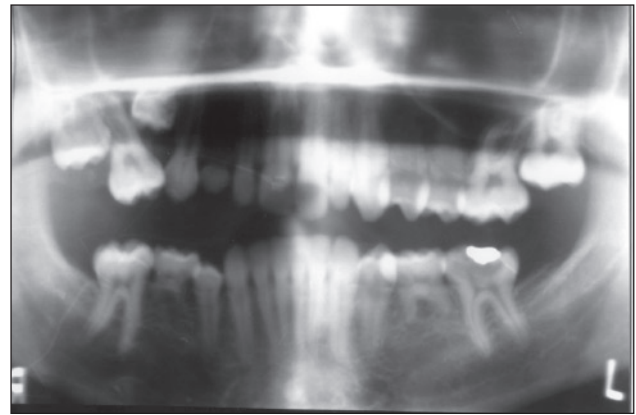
Panoramic radiograph of a 14-year-old female showing an impacted maxillary right primary second molar and no evidence of the development of several permanent teeth.
